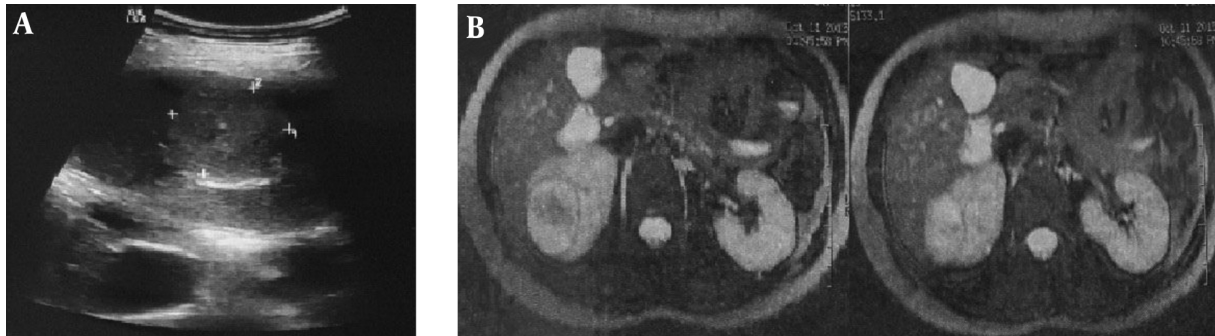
A, Ultrasound showing an isoechoic to mildly echogenic well-margined mass measuring 39 × 33 mm in the upper portion of the right kidney; B, Magnetic resonance (MR) image of a mass in the upper pole of the right kidney demonstrating heterogeneous signal intensity in the upper pole of right kidney.
